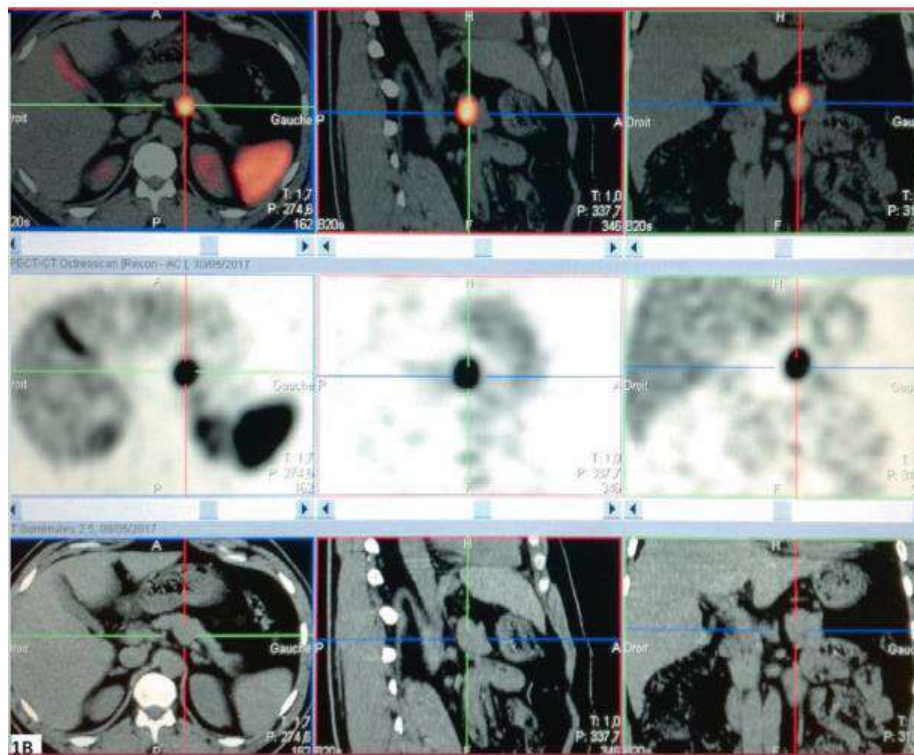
SPECT/CT image of a 99mTc-Tektrotyd® scintigraphy showing a focus of hyperuptake at the junction of the isthmus and body of the pancreas, corresponding to an insulinoma (representative case).
